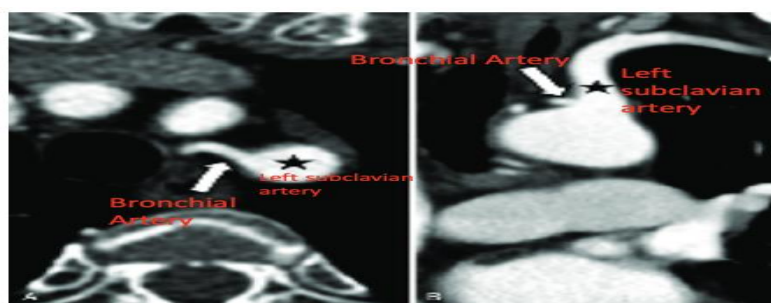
Ectopic bronchial artery from left subclavian artery. (A, B) Chest CT shows common trunk of bronchial artery (white arrow) originate from left subclavian artery (star).
